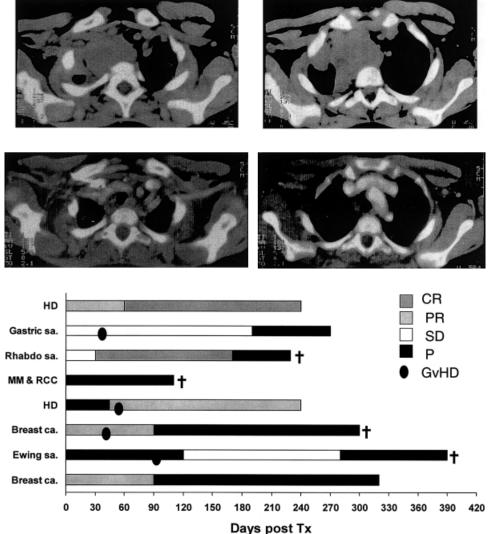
Computed tomography (CT) scan from a patient with rhabdomyosarcoma before (A,C) and 3 months after (B,D) the patient underwent allogeneic hematopoietic stem cell transplantation. CT scan sections are not fully superimposable; however, the overall interpretation of the images shows the regression of mediastinal tumor masses.
